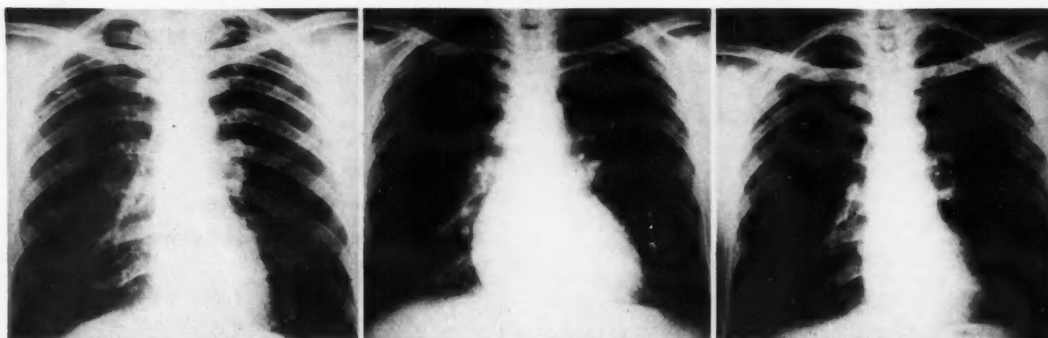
Left*, routine x-ray film of chest taken at time patient was hospitalized in February, 1953, for surgical procedure. Transverse diameter was 101 mm. *Center*, taken June 26, 1953, one day after admission to hospital for *P. vivax* malaria. Transverse diameter was 159 mm. *Right*, three weeks later, transverse diameter was 119 mm.
